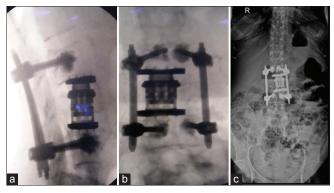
Case 2 – (a and b) Lateral and anteroposterior fluoroscopic image showing expandable cage with pedicle screw at L2 and L4. (c) Postoperative radiograph of lumbosacral spine at 4 months (anteroposterior) showing placement of the corpectomy cage and posterior pedicle screw fixation from L2 to L4.
